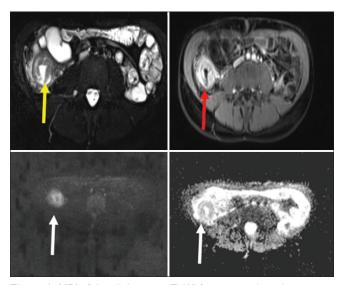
MRI of the abdomen in T2WI fat saturated axial sequence and axial T1WI fat saturated axial sequence with post contrast of active Crohn's disease demonstrates circumferential transmural distal ileum wall thickening (yellow arrow), submucosal edema, inflamed surrounding fat, trace of free fluid, and enlarged lymph node. The post contrast image showed avid mucosal enhancement consistent with active disease. The corresponding diffusion weighted image and apparent diffusion coefficient sequences (white arrows) demonstrate restricted diffusion, secondary to disease activity
